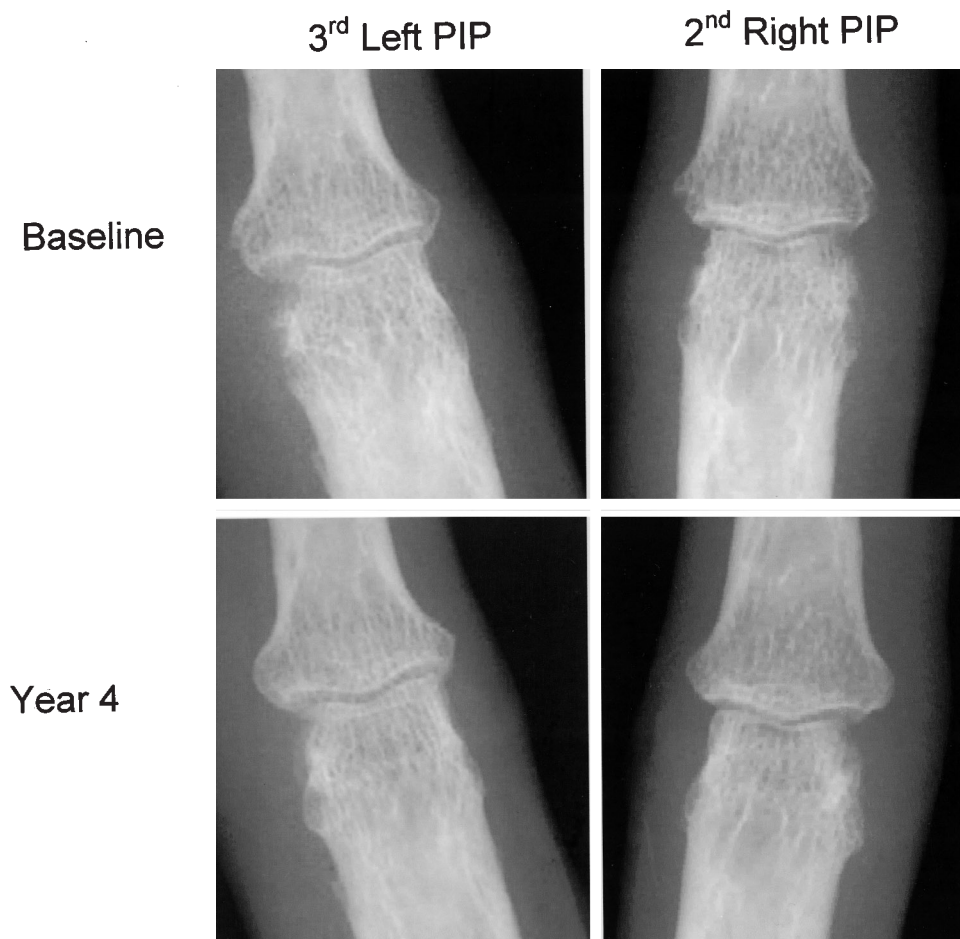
Left panels show radiographs of the 3rd left proximal interphalangeal (PIP) joint. At baseline the radial and ulnar surfaces show irregularity and scalloping with disruption of the cortex. At 4 years the irregularities are markedly improved and recortication is evident. Right panels show radiographs of the 2nd right PIP joint. At baseline the radial surface of the joint shows irregularity and cortical disruption. At 4 years recortication is evident.
